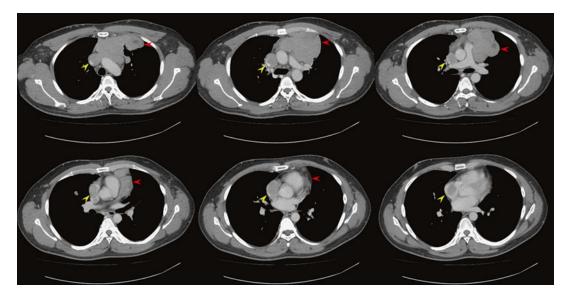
Contrast-enhanced CT images, showed a huge anterior mediastinal tumor with lung metastasis (*red arrows*) and extended into the SVC and RA (*yellow arrows*)
